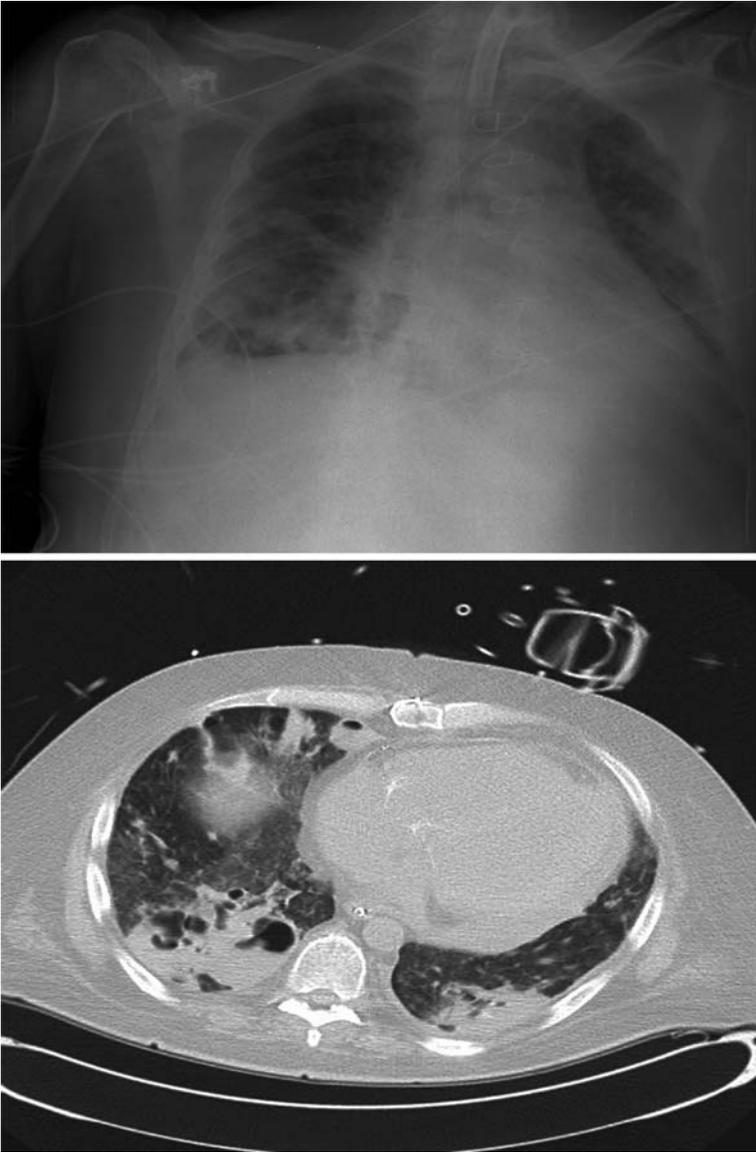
Chest X-ray and CT scan 2 months post kidney transplantation for end stage diabetes. Bilateral lower lobe cavities with adjacent pleural effusion on the right side are seen. Transbronchial biopsy revealed *Aspergillus fumigatus*. Serum and BAL galactomannan was 0.1 and 5.7 ng/ml, respectively. Despite antifungal treatment, patient died of proven *Aspergillus* endocarditis of the tricuspid valve
